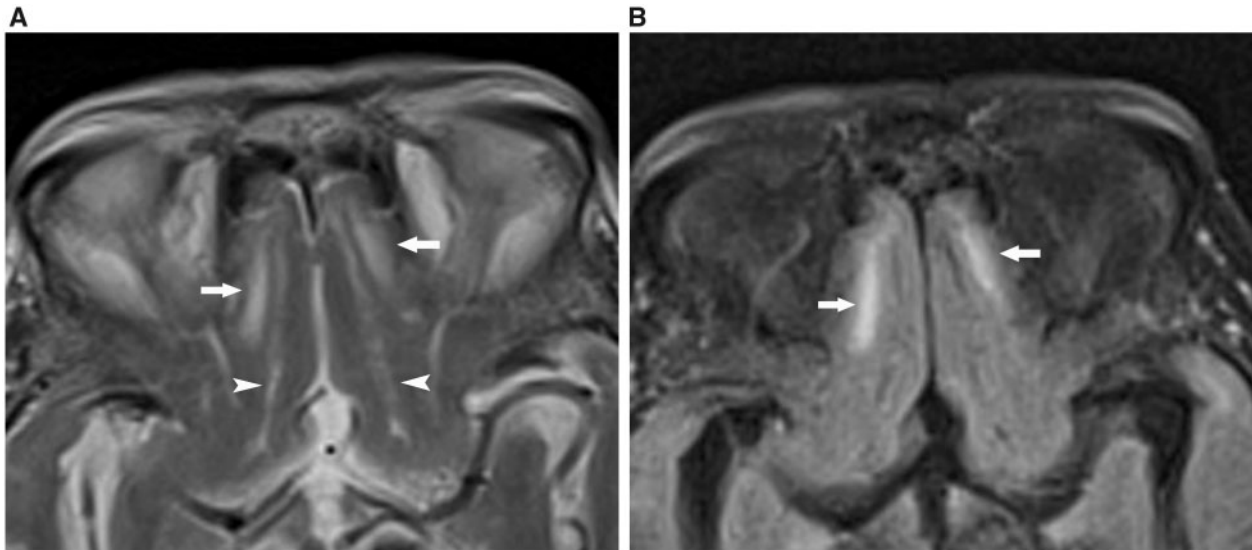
MR images in a 68-year-old woman with anosmia undergoing evaluation for COVID-19 infection. (A) Axial T2-weighted brain MR image shows bilateral areas of high signal intensity (arrows) in rhinobase adjacent to the olfactory sulci (arrowheads). (B) Corresponding axial FLAIR image shows high-signal-intensity infarcts (arrows), in distribution of the olfactory tract.
